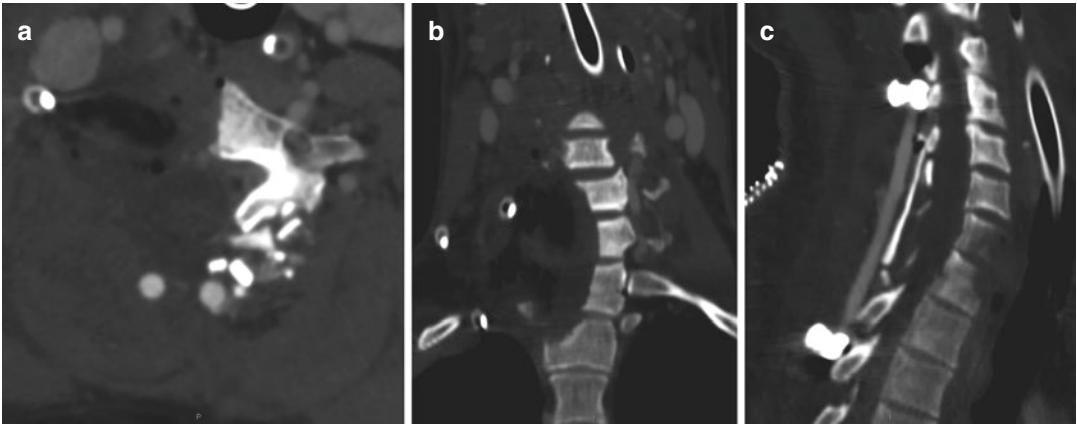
Postoperative CT scan proving the result of the performed resection
